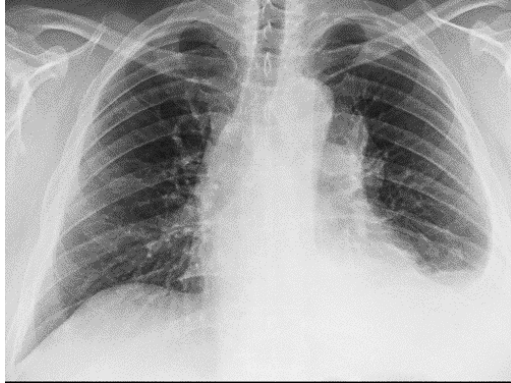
Postero-anterior pulmonary radiography of the patient.
